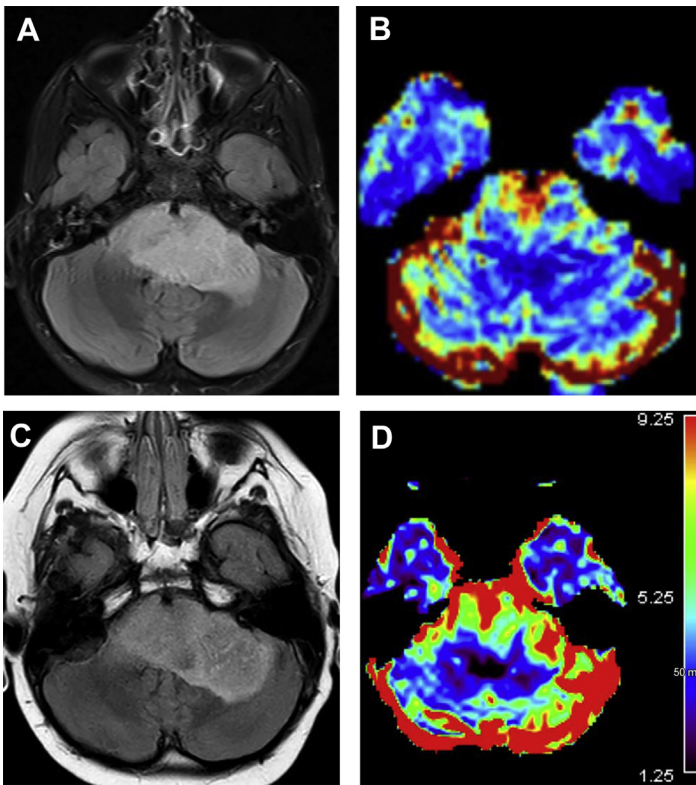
A 6-year-old girl with diffuse intrinsic pontine glioma was enrolled in a clinical trial. Initial FLAIR image (A) and corresponding CBV map (B) show significant expansion and FLAIR hyperintensity of the pons and left middle cerebellar peduncle with increased rCBV parameters primarily in the pons. Repeat MR imaging after multiple cycles of chemoradiation shows further increase in extent of FLAIR hyperintensity along the left (C) and significant increase in rCBV in both the pons and left middle cerebellar peduncle (D) suggesting neoplastic PD.
